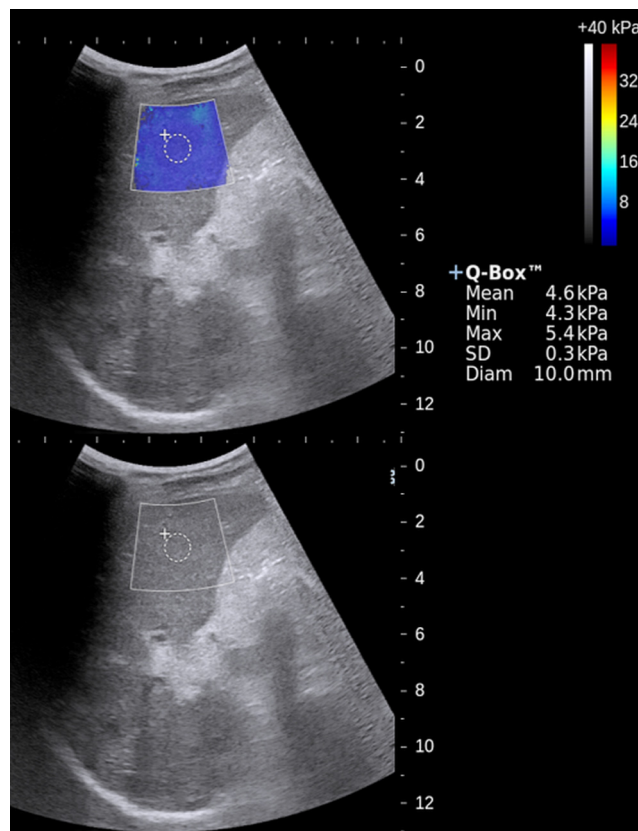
Ultrasonography image of right lobe of liver with SWE and Q box for measurement of liver stiffness.
